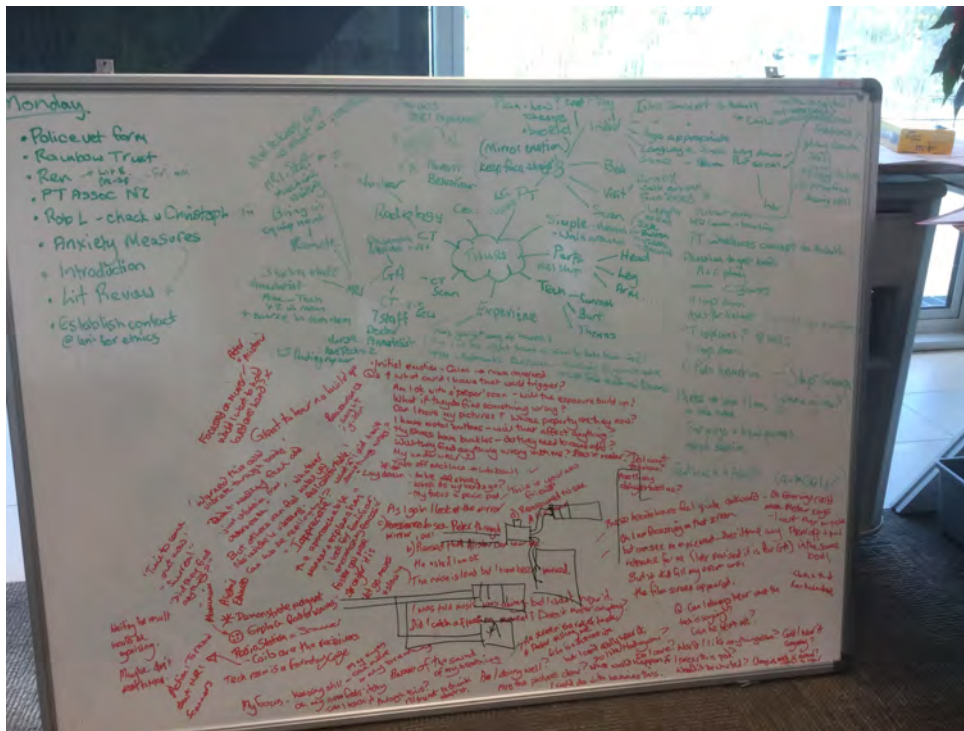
First hand user experience of MRI brain scan - thoughts and emotions
